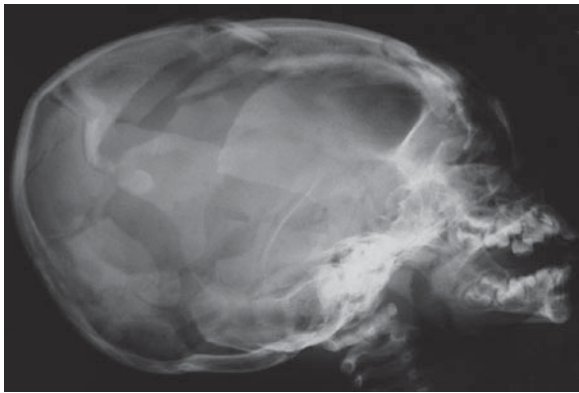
The skull radiograph of a 1-year-old girl who was thrown from the fifth floor of an apartment building by her carer shows a crushed skull
